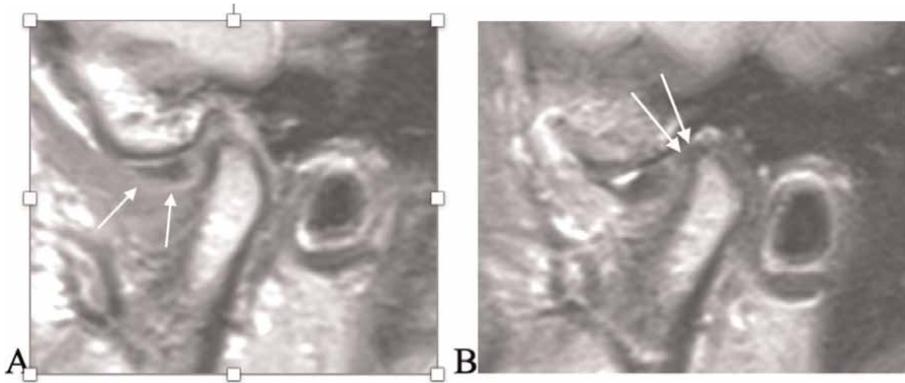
MRI of the TMJ. A – Anterolateral location of the disk without reduction (↑↑↑) in the left TMJ. B – Anterolateral disk location without reduction with partial rupture of the posterior discotemporal ligament (↑↑↑) of the right TMJ.
